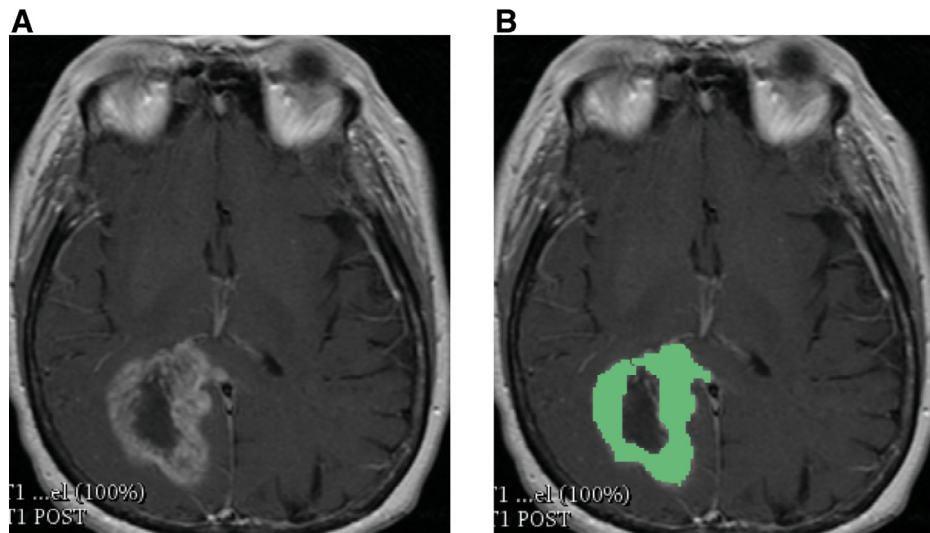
Glioblastoma multiforme (GBM) segmentation of tumor on postcontrast T1-weighted images of a 74-year-old GBM patient with an overall survival of 110 days. Before (A) and after outlined tumor (B) image were shown for tumor segmentation. (Color version of figure is available online.)
